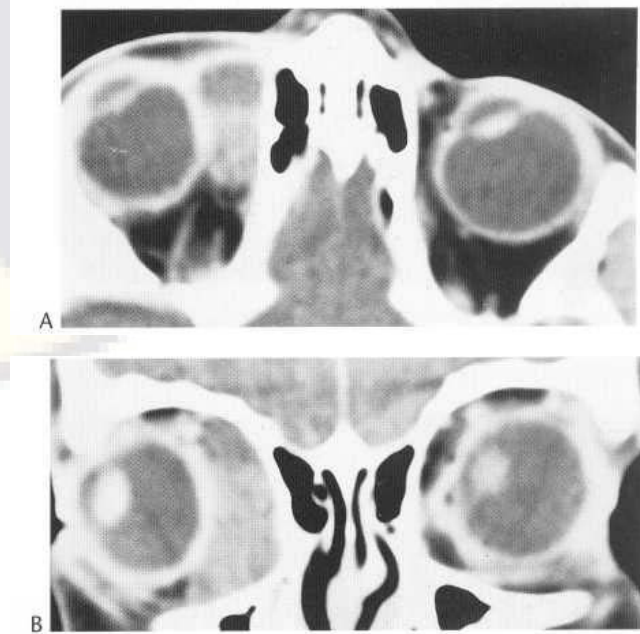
Lymphangioma. Supine axial (A) and prone corona (B) enhanced CT images demonstrate a complex intraorbital mass medial to the right globe. Fluid-fluid level is characteristic for haemorrhage, and consistent with the clinical history of acute proptosis and ocular pain. (Case courtesy of Orlando Ortiz, M.D.)
